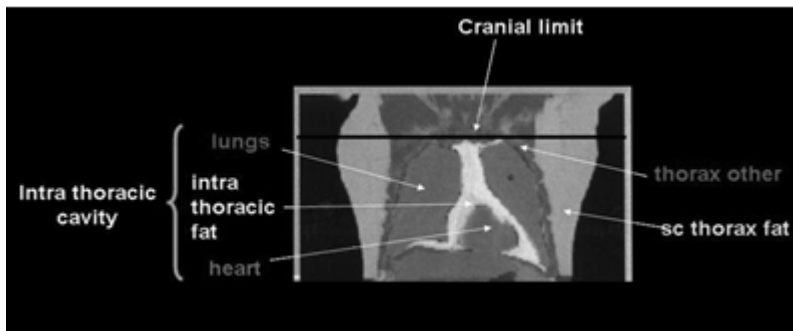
Coronal section of magnetic resonance imaging (MRI) scan of thorax in an obese man, shaded to show lungs, heart, and intrathoracic fat (mainly pericardial). For clarity, this scan was acquired with the subject supine, but with his arms extended above his head.sc, Subcutaneous
